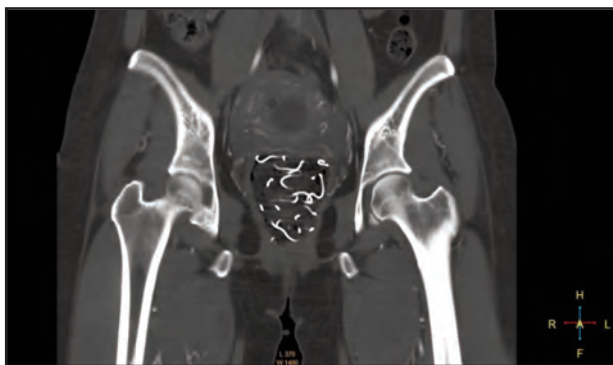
CTA of the pelvis
